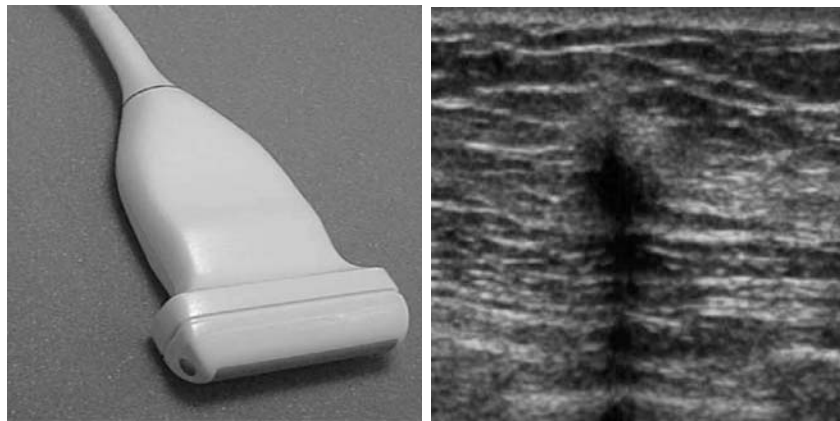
Ultrasound image of breast cancer.
